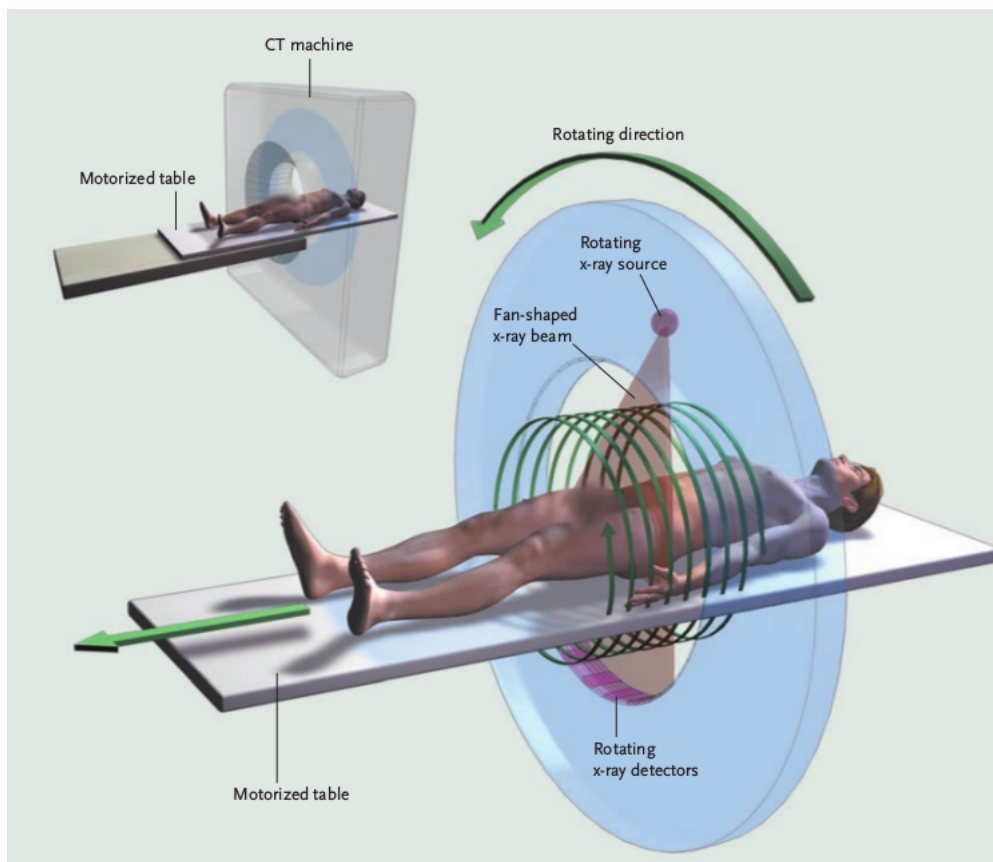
Representation of CT imaging system
